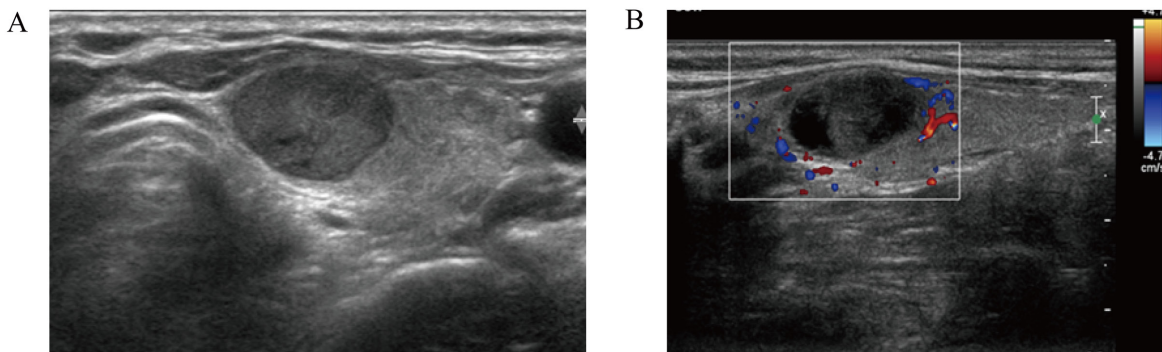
Case 1: Warthin-like variant of papillary thyroid carcinoma in a 47-year-old woman who was diagnosed with papillary thyroid carcinoma in a background of cystic degeneration on fine-needle aspiration cytology. Transverse (A) and longitudinal (B) ultrasonography show a 1.5-cm well-defined, hypoechoic, wider-than-tall nodule with internal cystic component in the right lobe of the thyroid gland.
